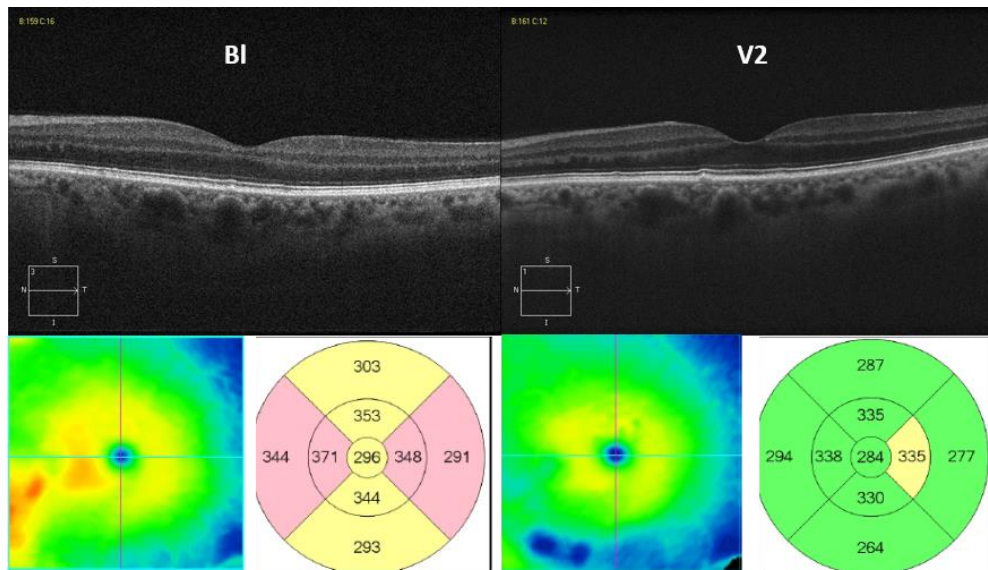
Choroidal morphologic changes in Retinal improved progression. From baseline (left) to V2 (right) there was a moderate increase in CT (+ 42 μ) and focal decrease in RT (Retinal thickness maps below the line scan images). We can observe on BL two focal zones where there is a hypertrophy of the choriocapillaris/Staller's layer (temporal and nasal of the center) that on the nasal one corresponds to some irregularities of retinal layers (Outer plexiform). On V2 there is a recovery with great vessels on the temporal focal zone, but not on the nasal zone where persists the retinal irregularities.
